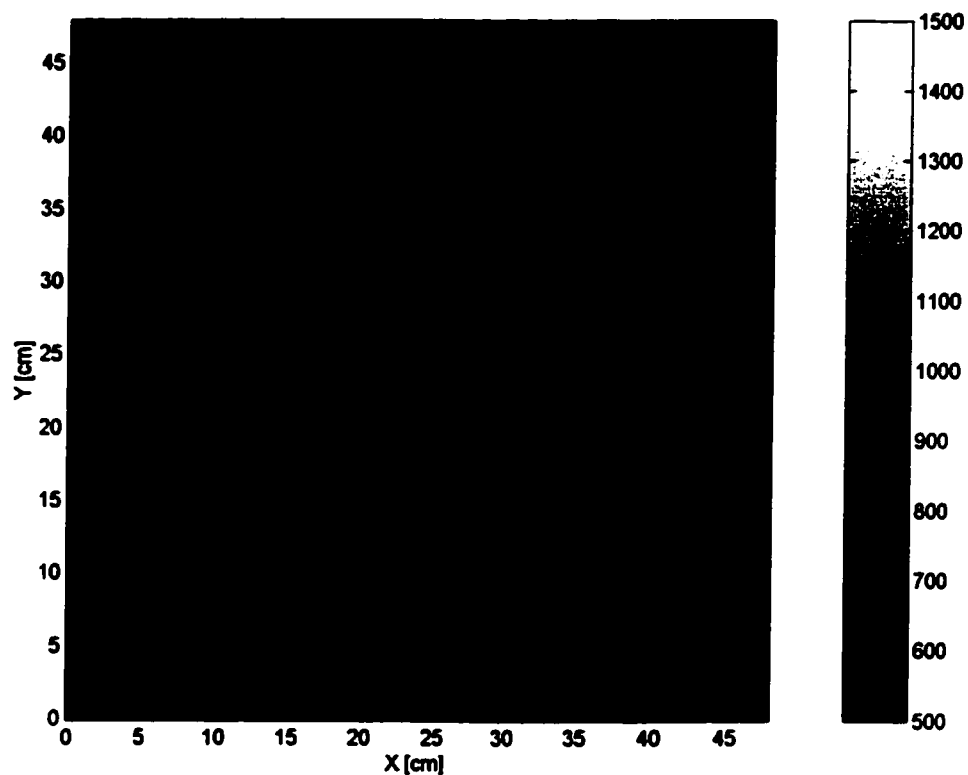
An example of CT image artifacts from the time-dependent signal with little density variation.
